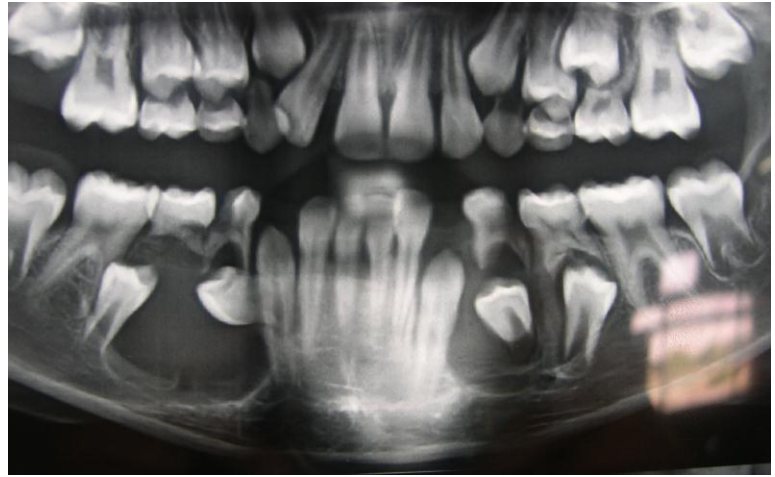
Panoramic radiograph showing two cyst like radiolucencies in relation to 44, 45, 34 & 35.
